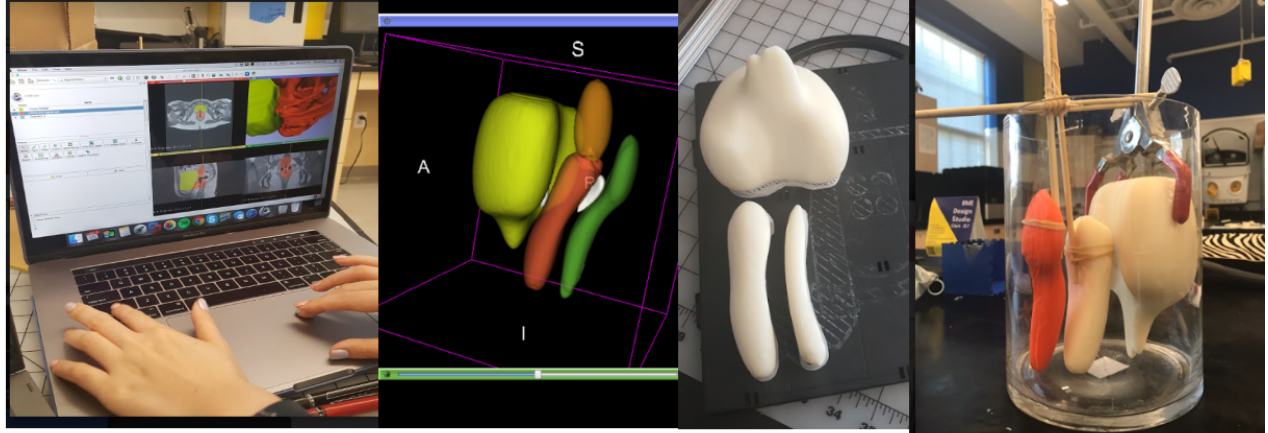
Patient MRI scans were used for manual volume segmentation in 3D Slicer software to generate .STL files. These files were then exported and 3D printed to form molds.
